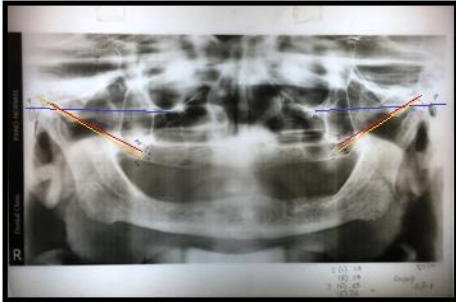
Radiographic analysis for patients over 50 years, edentulous for more than 1 year and not wearing dentures
